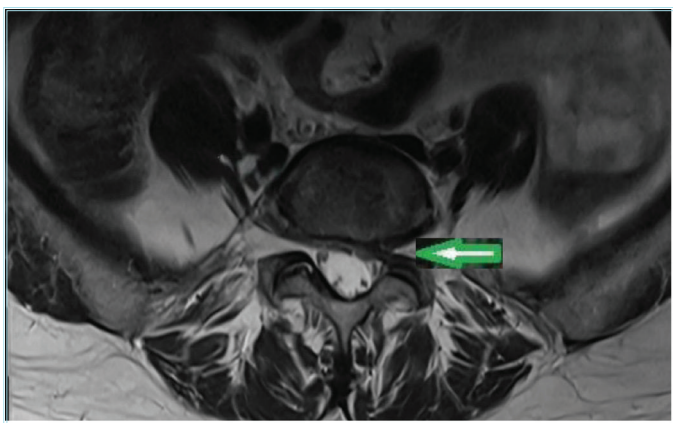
Disc bulging is shown on the T2-weighted
